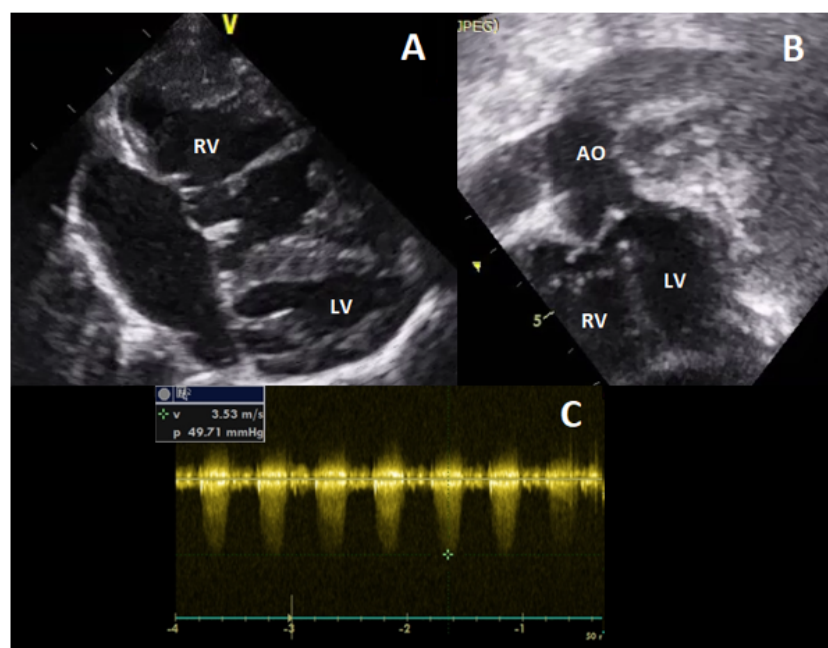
Transthoracic echocardiography (A): Subcostal four chamber view showing a dilated and hypertrophied RV; (B) Subcostal view showing an overriding aorta with a large subaortic VSD; (C): continuous wave Doppler on pulmonary valve showing a peak systolic pressure gradient at 49,7 mmHg suggestive of pulmonary valvular stenosis. *RV: Right ventricle; LV: Left ventricle; Ao: Aorta; VSD: Ventricular septal defect.
